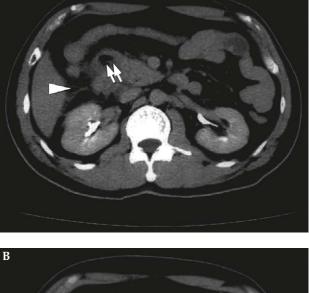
(*A*, *B*) Abdominal computed tomography performed on admission shows the diverticulum (double arrows) over the distal second portion of the duodenum (double arrowheads), and linear infiltration in the retroperitoneal and right anterior pararenal space (single arrowhead).
